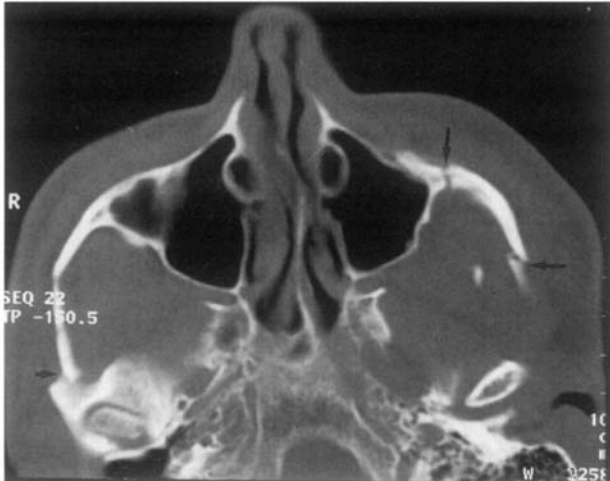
Axial CT image of blunt trauma victim shows isolated double left zygomatic arch fracture (arrows). The posterior right zygomatic arch is also fractured (arrowhead). The maxillary and other paranasal sinuses (not shown) were clear.
